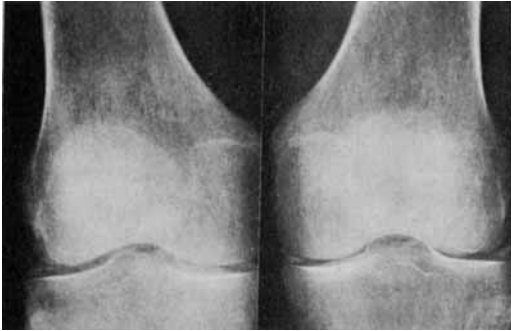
Radiograph of knees showing chondrocalcinosis in both menisci.
